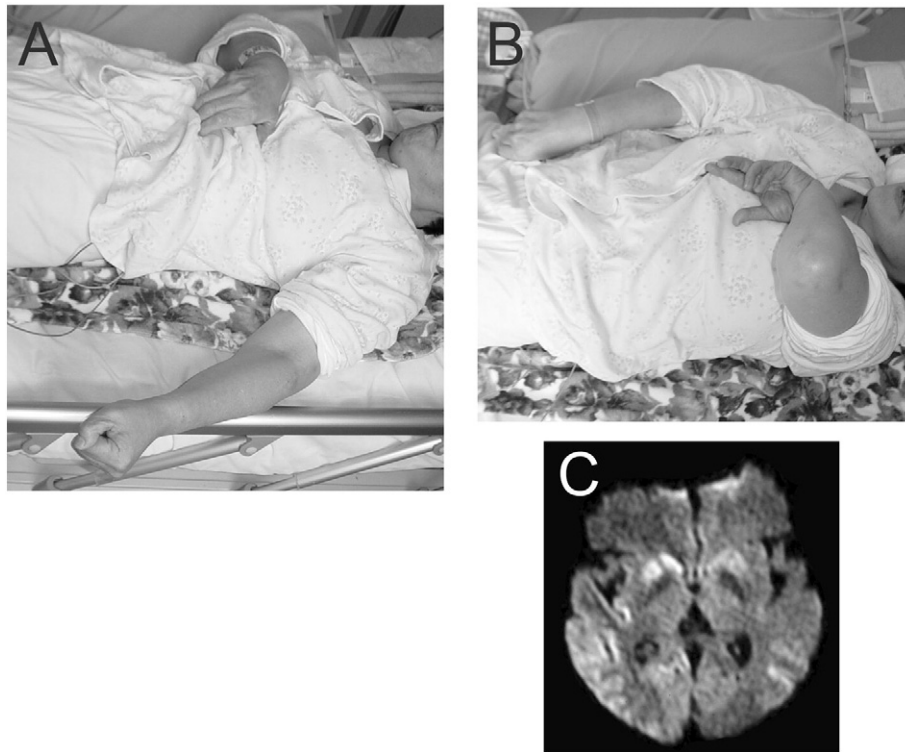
Photos of the dystonia. There were two patterns of dystonic posture in the left upper extremity: (A) the shoulder abduction, elbow extension, and grasping, and (B) the shoulder flexion and abduction, elbow flexion, forearm pronation, and wrist flexion. The right upper extremity showed elbow flexion and grasping. DWI-MRI revealed hyperintensities involving the bilateral temporooccipital lobes, caudate heads, and anterior parts of the putamen (C). The hyperintensities were more remarkable on the right side of the brain.
